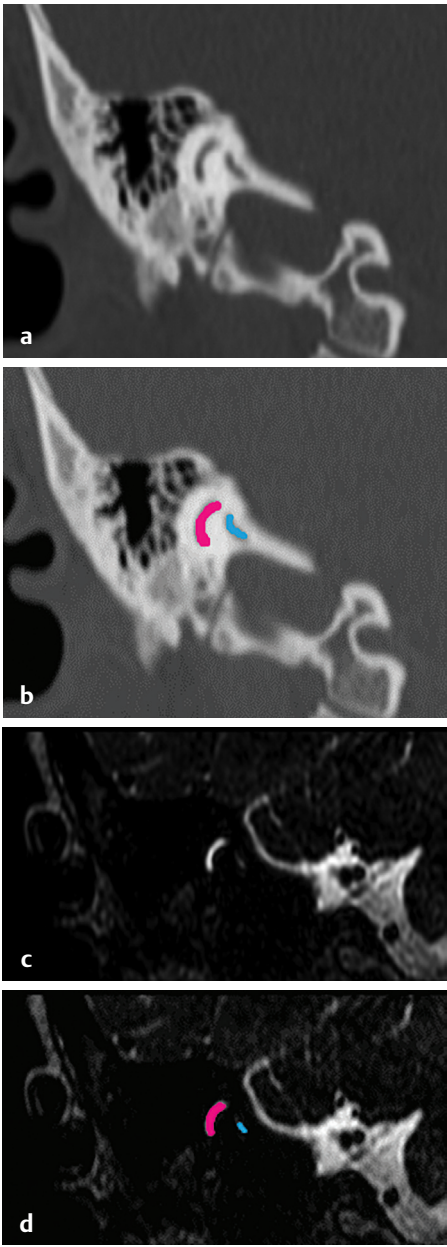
(a, b) HRCT temporal bone, coronal section, bone window and (c, d) MRI CISS/FIESTA sequence show (pink) posterior semicircular canal, (blue) vestibular aqueduct.
